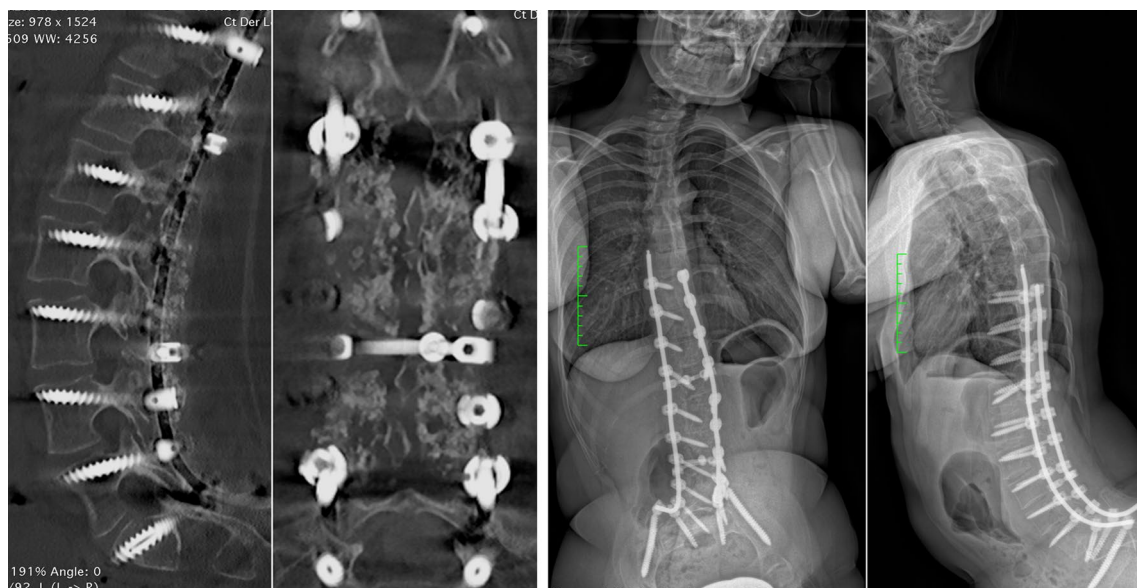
a Exemplary CT reconstructions in the sagittal plane and in the coronal plane at 2 years after completion surgery. A solid posterior fusion mass, an unchanged correction and a stable construct without implant loosening or failure can be seen. b Sitting EOS full
